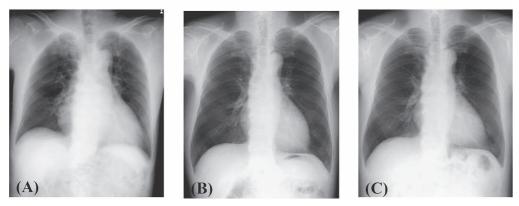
Changes in the findings of chest radiography after laparoscopic adrenalectomy. Chest radiography on admission (A), 1 week after laparoscopic adrenalectomy (LADX) (B), and 2 years after LADX (C). Pulmonary congestion and cardiac enlargement found on admission improved immediately after LADX, and remained recovered for two years after LADX.
